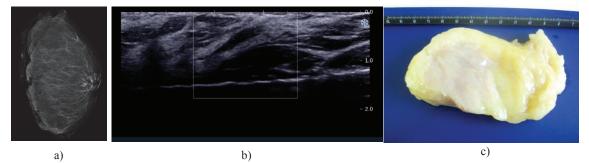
a) X-Ray image of the whole soft-embalmed human breast. b) Ultrasound image of the whole soft-embalmed human breast. c) Dissected human breast tissue before sonications.
